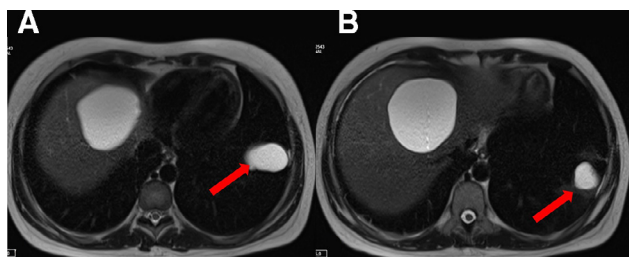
In the unenhanced T2-weighted image, 2 hyperintense type-1 hydatid cyst with thin hypointensation wall with left lower lobe in the left lung.
